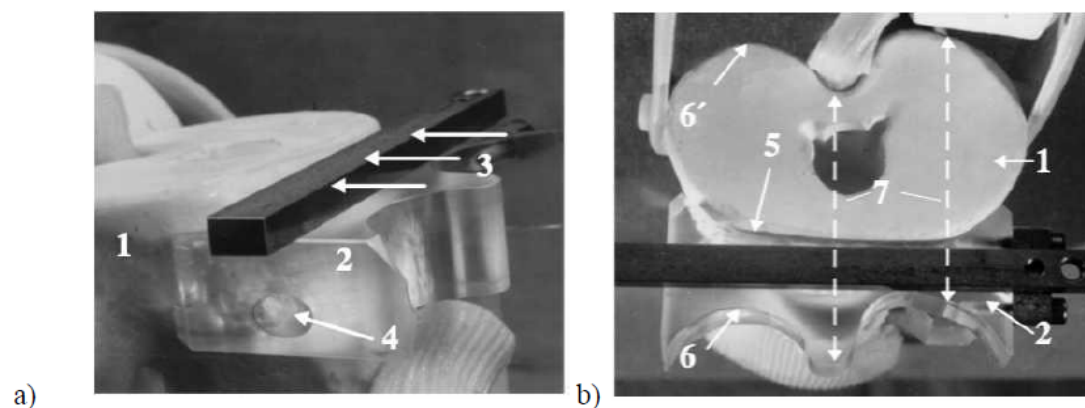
Individual template for guiding a tibial osteotomy for total knee arthroplasty – laboratory tests on a plastic model of a knee joint (1): a) The CT image-based customized template (2) precisely aligns the plane of the reference osteotomy (3). Optionally, the template can be fixed by bone pins (4). b) The CT image-based adapted contact surface (5) and contour to be copied (6) limit the depth of cut (7) to the dorsal surface contour (6') of the tibial bone.
